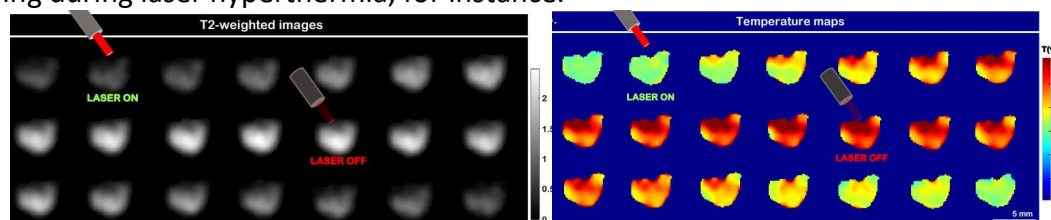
T2-weighted and temperature images obtained with a cell sample before, under NIR irradiation for 82 s at 0.67 W cm^{-2} , and after that irradiation (8 s integration time per image, pixel size of 0.16 mm). (From [1])
